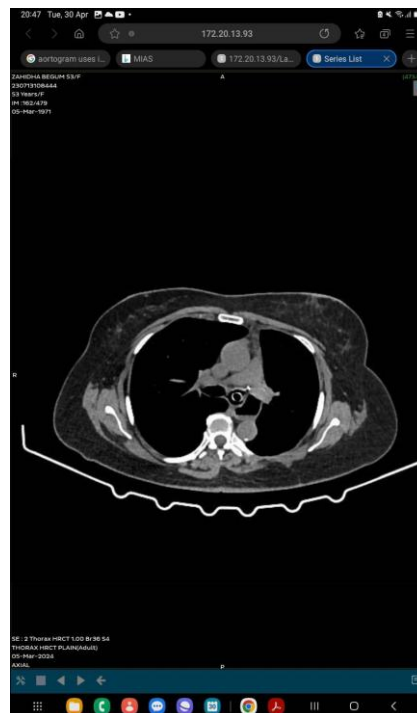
Contrast-enhanced CT demonstrating extrinsic compression near the left hilar airway and adjacent mediastinal structures.
